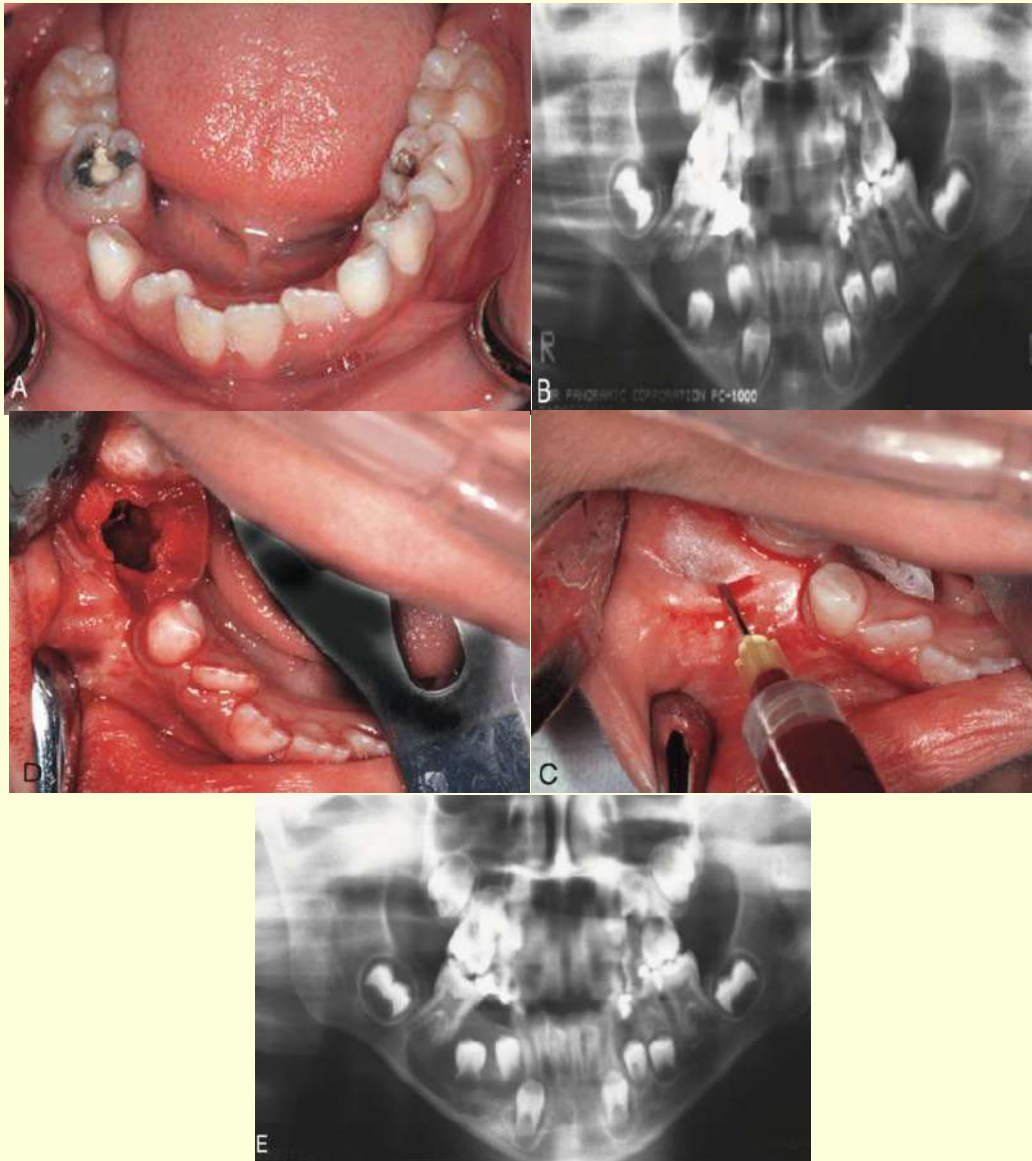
Marsupialization of cyst in right mandible associated with unerupted teeth. A- Photograph showing swelling around right second deciduous molar. B- Radiographic appearance before marsupialization.
